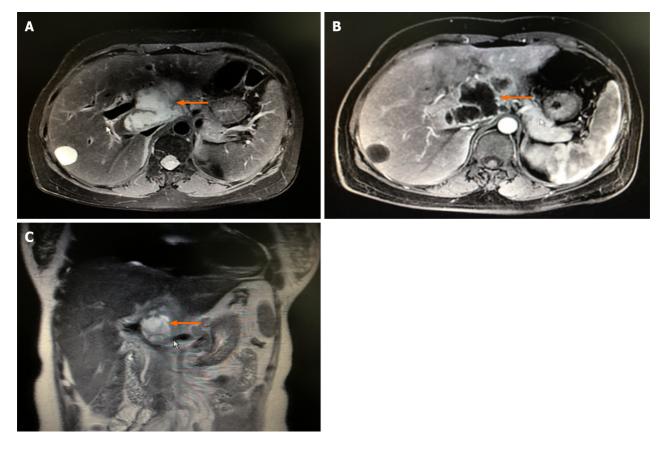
Enhanced magnetic resonance imaging of the liver. A and C: A space-occupying lesion (orange arrows) is seen axially (A) and coronally (C) in the caudal lobe of the liver, with unclear borders and irregular shape, about 7.6 cm × 4.4 cm × 5.0 cm in size, slightly low signal on T1WI and slightly high signal on T2WI, and inhomogeneous signal; B: The edge of the tumor is enhanced in the arterial phase, with multiple small and disorganized vascular shadows present within the lesion. Considering the possibility of cystadenocarcinoma, it was considered in differential diagnosis of liver abscess.
